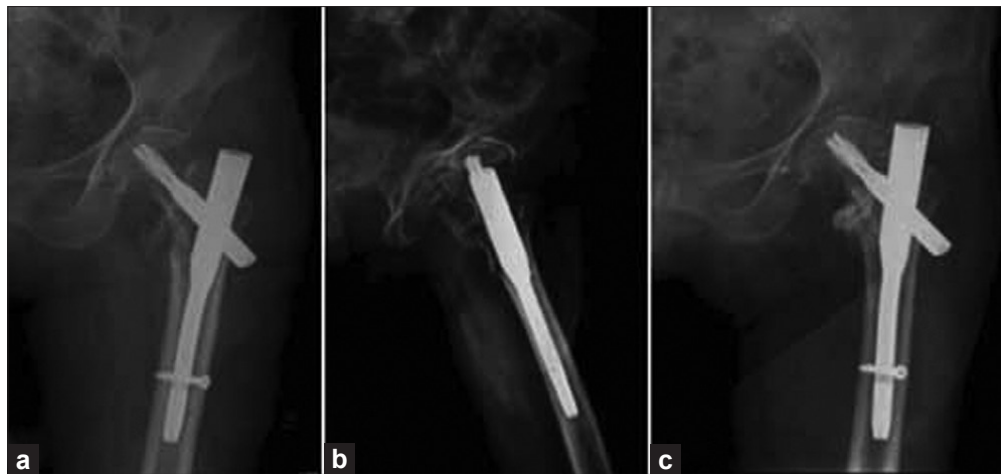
X-ray (L) hip joint anteroposterior view (a) and lateral view (b) showing a well-reduced type AO; 31-A2 fracture fixed with the PFNA demonstrating excellent blade position and (c) satisfactory outcome at final followup
